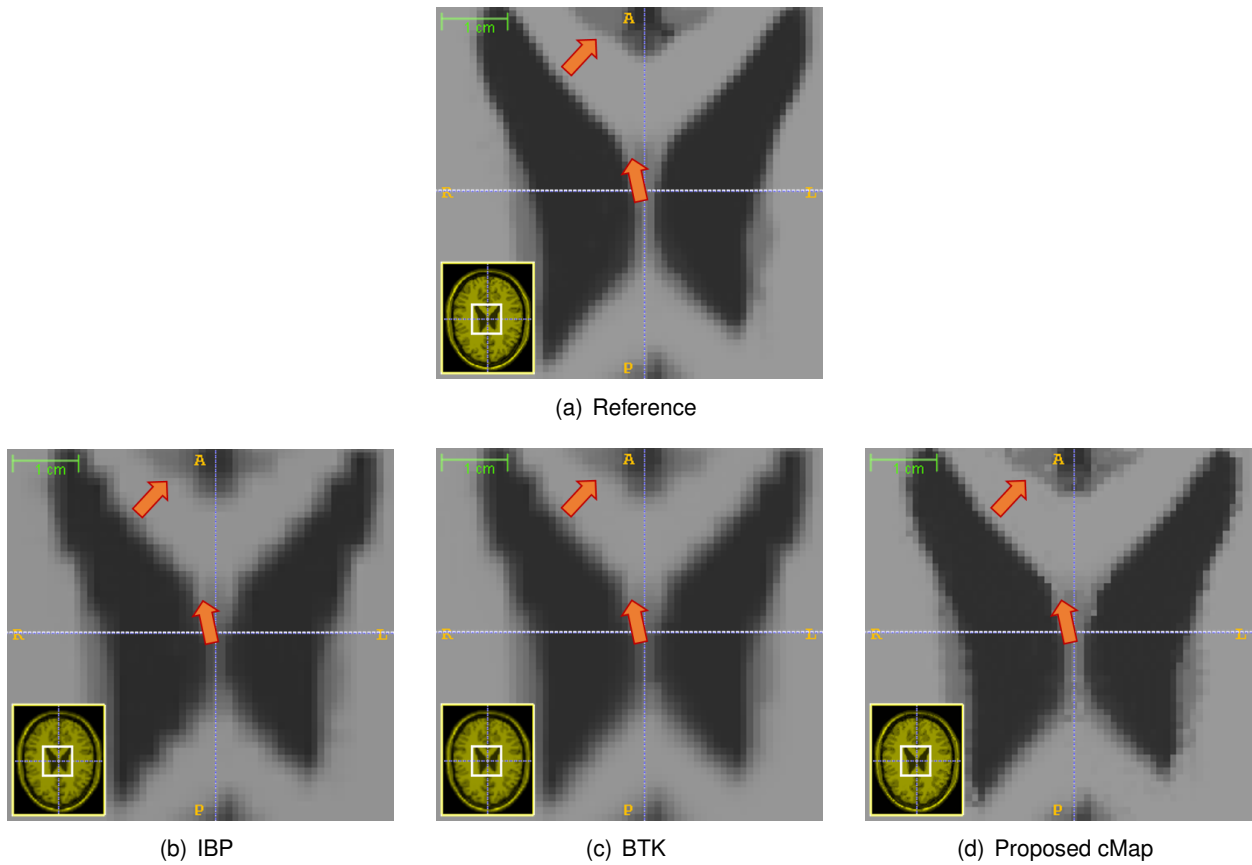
Comparing reconstruction quality of small details after applying various SRR techniques on MR images.
